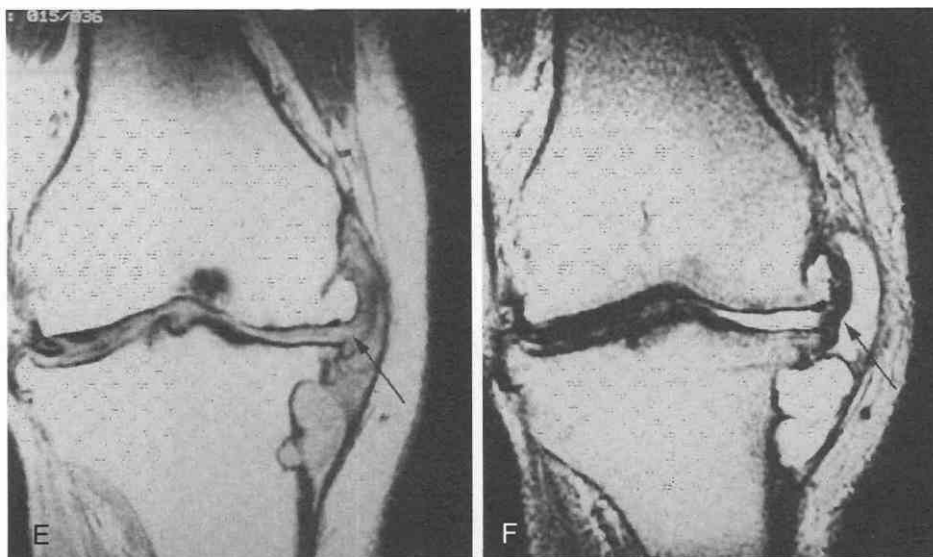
Continued.* E and F, Coronal proton-density-weighted and T2-weighted images show the cystic structure communicating with the osteoarthritic joint. The lateral meniscus is degenerated, and what remains of the medial meniscus has been displaced beyond the joint margins (arrow). A meniscal cyst was found at surgery.
